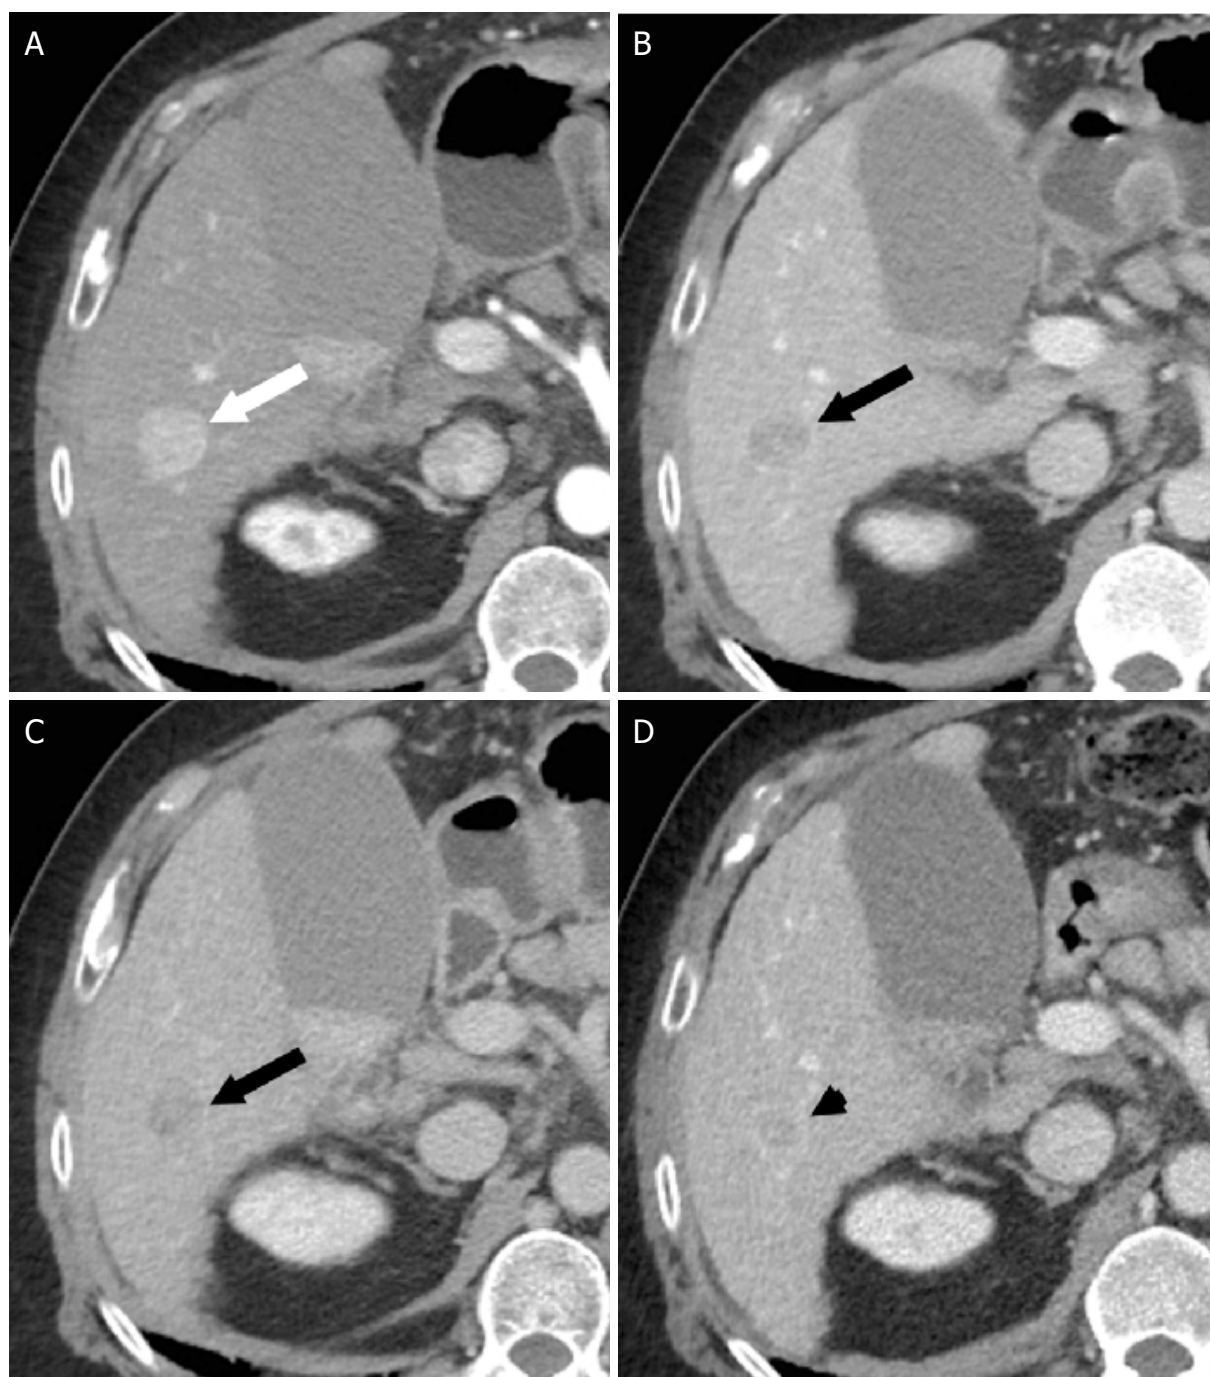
Threshold Growth. Axial CT images of a 21 mm mass in the right hepatic lobe. The mass demonstrates arterial phase hyperenhancement during the arterial phase (white arrow, A), and “washout” with “capsule” (black arrow) on the portal venous (B) and delayed phases (C). Axial CT performed 5 months prior demonstrates a 12 mm mass on the portal venous phase (D, black arrowhead). The interval growth is more than 50% in less than 6 months, therefore, the mass also demonstrates threshold growth. The most appropriate category for this mass is LI-RADS 5. CT: computed tomography; LI-RADS: Liver Imaging Reporting and Data System
